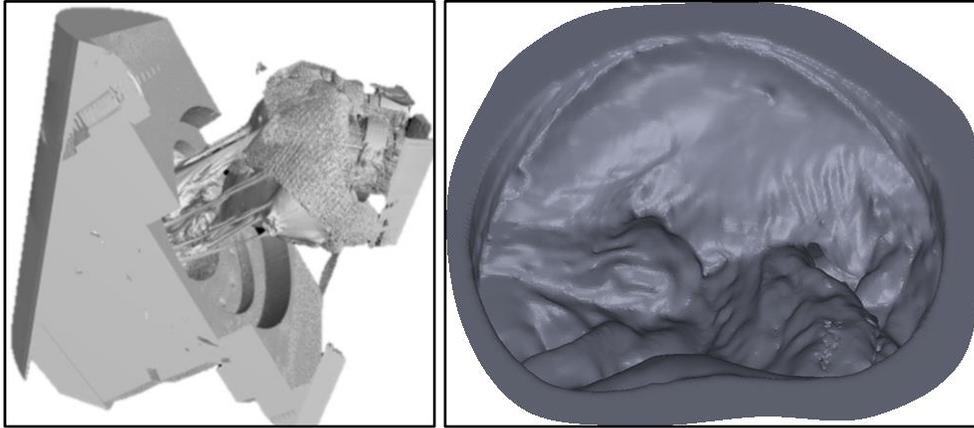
Reconstructed 3D μ CT scan data of MV from ventricular side with hardware. Figure 7. Reconstructed 3D μ CT scan data of closed MV leaflets from atrial side.
